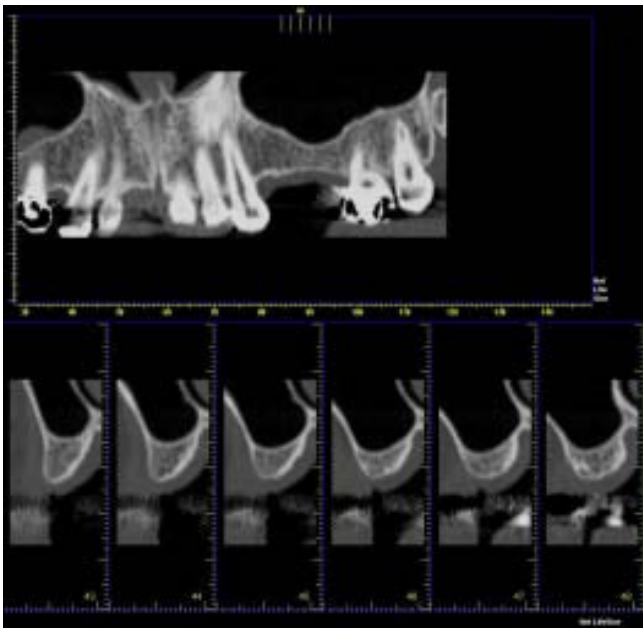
Presurgical CT scan used to determine the correct position of the bony window and to measure the thickness of the lateral sinus walls. The bone height was 4 mm. No sinus pathology was present.
